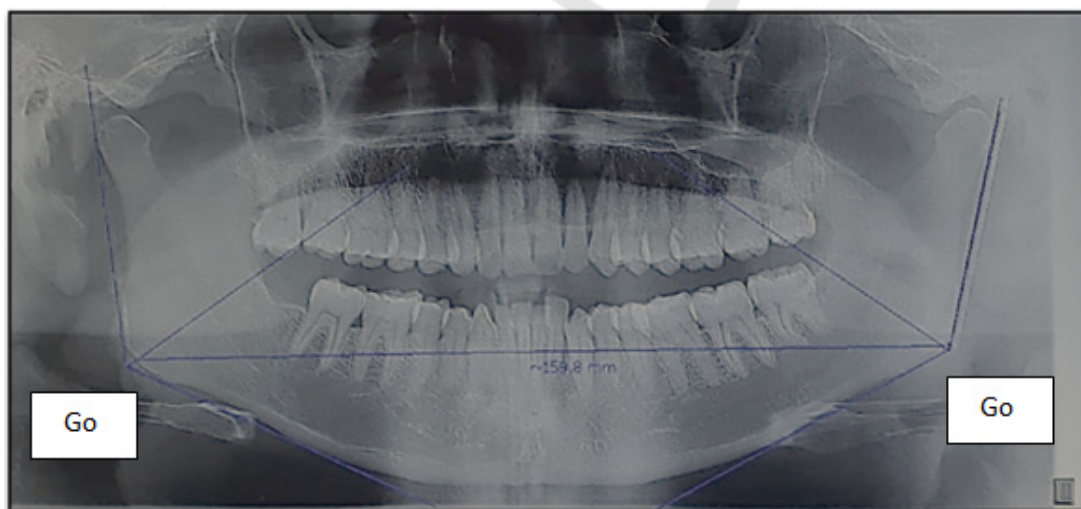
Bigonial width in panoramic radiograph (private document).
